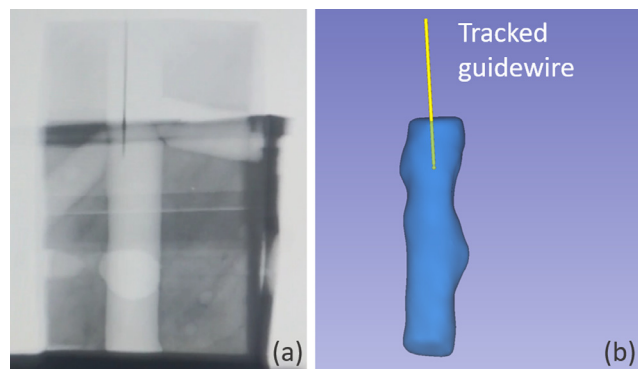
An example use case for navigating a tracked guidewire within the ultrasound-reconstructed vessel (b) as compared with the fluoroscopic equivalent (a).
